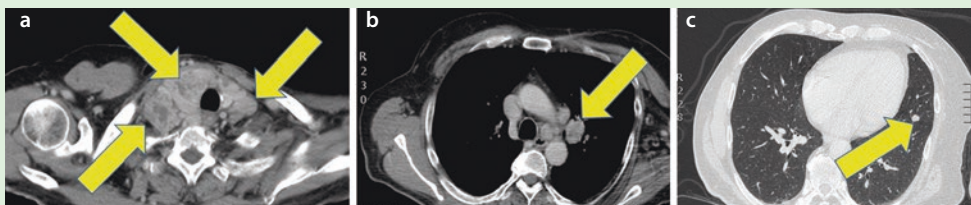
Contrast-enhanced CT images in venous phase of neck a and thorax b, c demonstrating locally invasive MTC with cervical and hilar lymph node metastasis and lung metastasis (yellow arrows)
